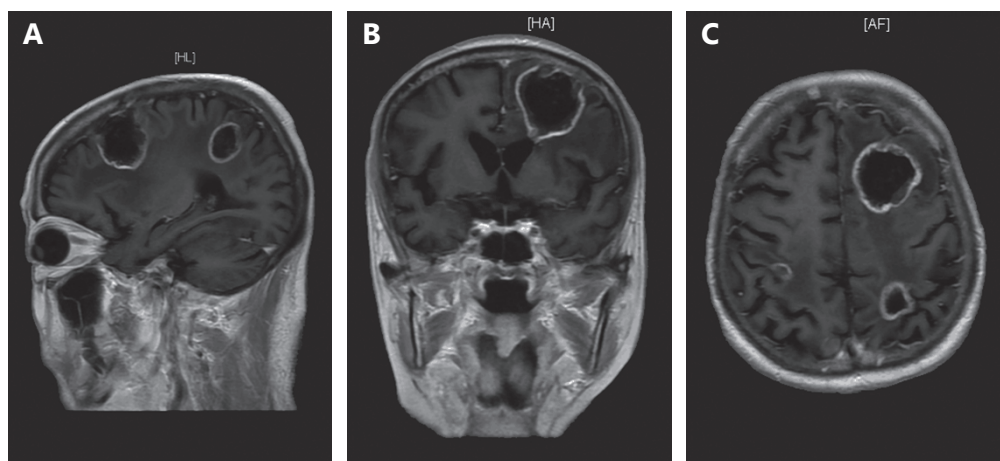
Case 2: pre-radiotherapy brain MRI revealed multiple fronto-parietal metastases in November 2015.
